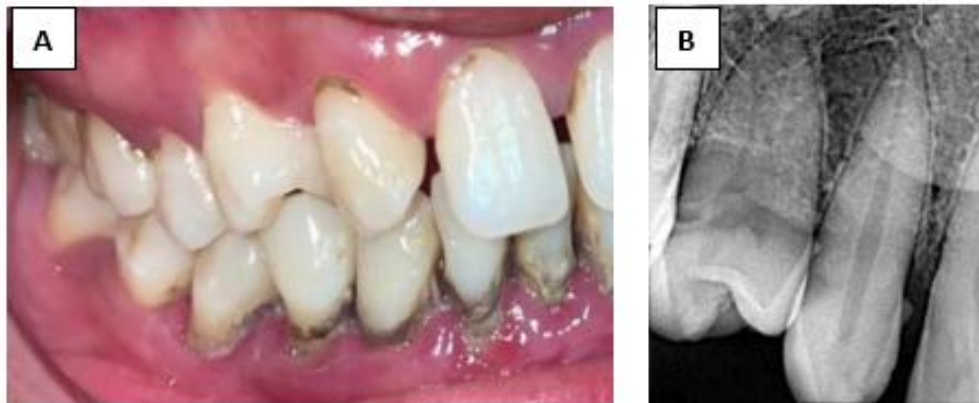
(A) Clinical presentation, (B) periapical radiographic
